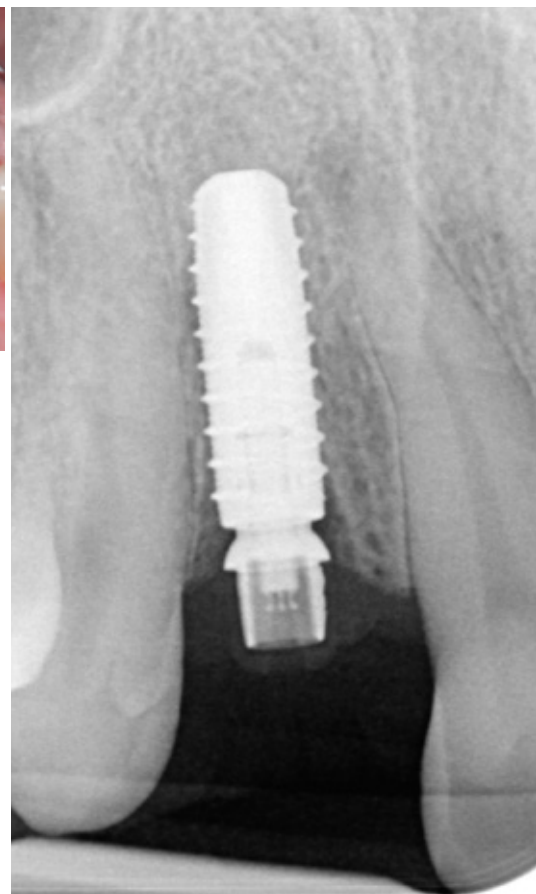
Control radiograph after implant placement (iSy implant diameter 3.8 mm, length 11 mm).
